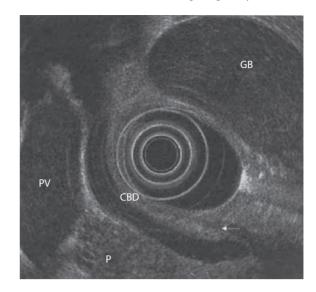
Endoscopic ultrasonography. CBD, common bile duct; GB, gallbladder; PV, portal vein; P, pancreas.
